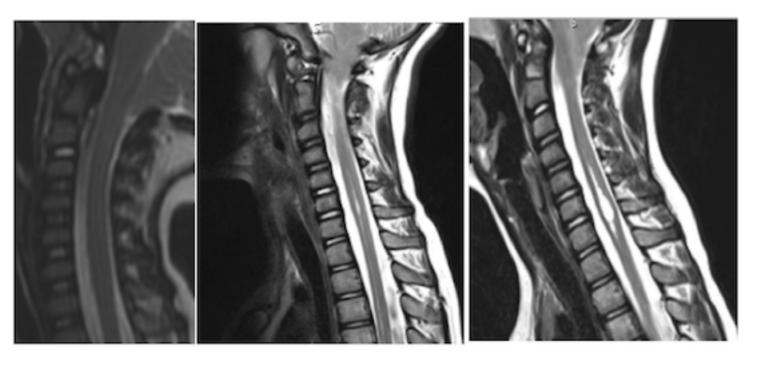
Case 1404P, patient affected by cervical and thoracic. Here the evolution of the centromedullary injury can be observed from its beginning to the formation of the syringomyelic cavity. On the MR image of the cranio-cervical region on the left hand side, taken in 2010, patient two years old, two parallel lines that follow the centre of the spinal cord can be seen, medullary ischemia-edema phase. On the image in the centre, at the age of five, we see the beginning syringomyelic cavity where the tissue necrosis due to ischemia appears (compatible with the conventional concept of the benign dilation of the ependimary canal). On the right hand side, now six years old, with the syringomyelia cavity at tension. We can also observe the progression of the descent of the cerebellar tonsils and of the tension of the cervical spinal cord.
